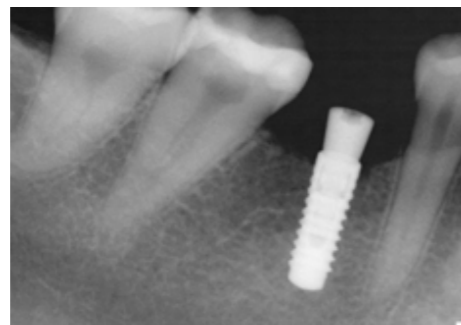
Radiograph demonstrating final implant position
